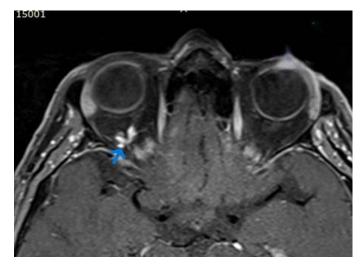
Postcontrast magnetic resonance imaging fragments of Patient D., 65 years old.
